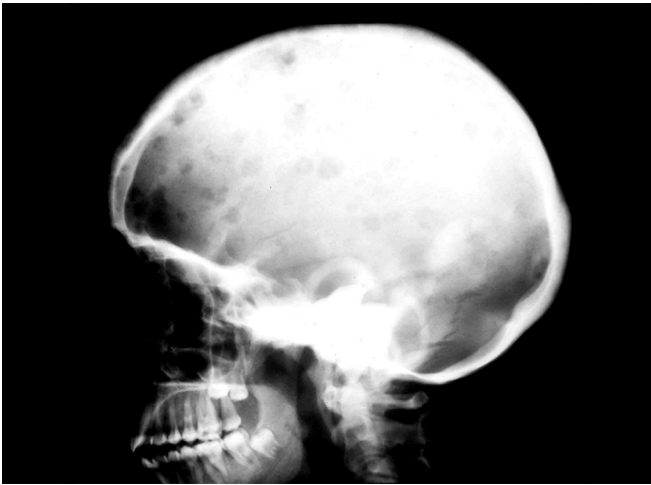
Hyperparathyroidism. Lateral skull radiograph shows multiple well-circumscribed rounded lytic lesions involving skull vault with bone within bone appearance—an unusual feature of hyperparathyroidism
